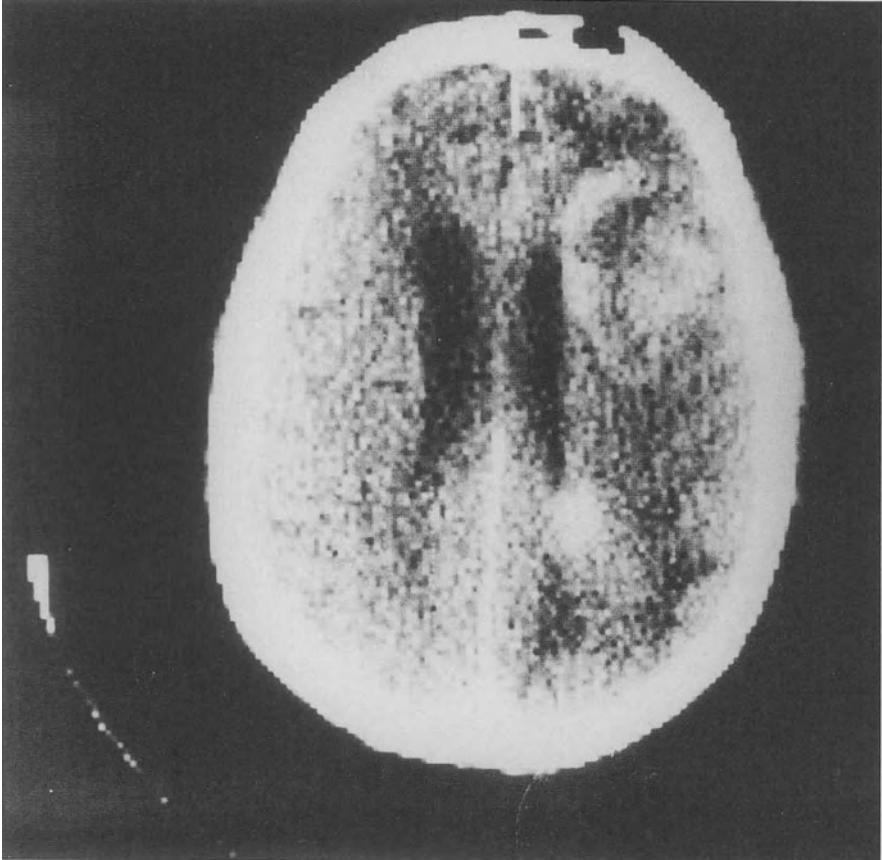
Apparent multicentric growth on CT scan
